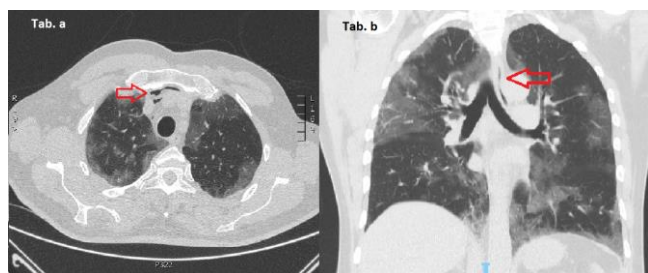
Chest CT-angiography executed on day 8 of admission; axial scanning plane (a) and coronal scanning plane (b). The red arrow indicates an upper pneumomediastinal leak in the anterior mediastinum
